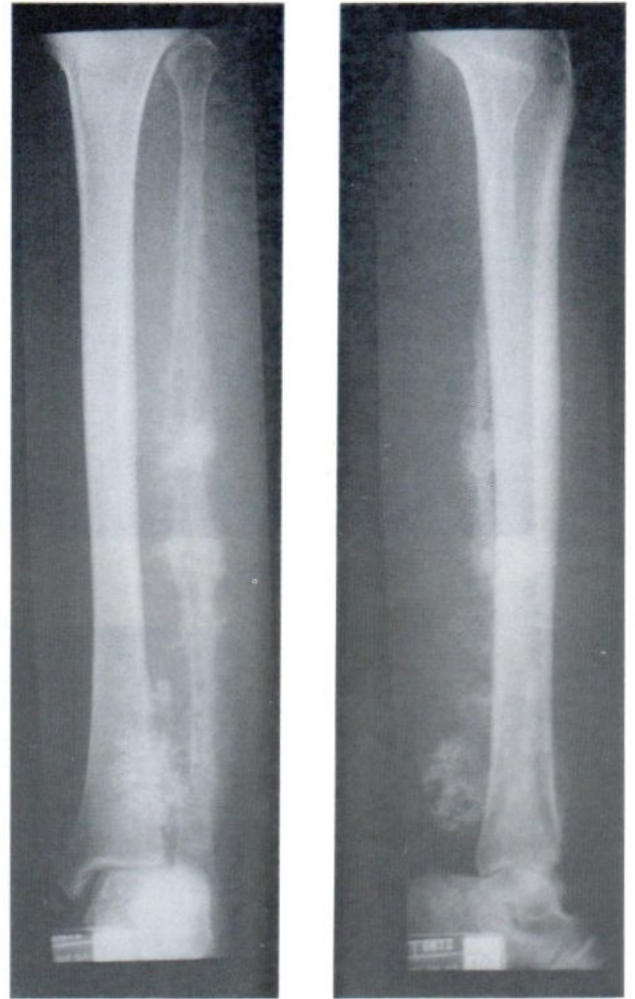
Classical chondrosarcoma at the left fibula was shown by radiography
